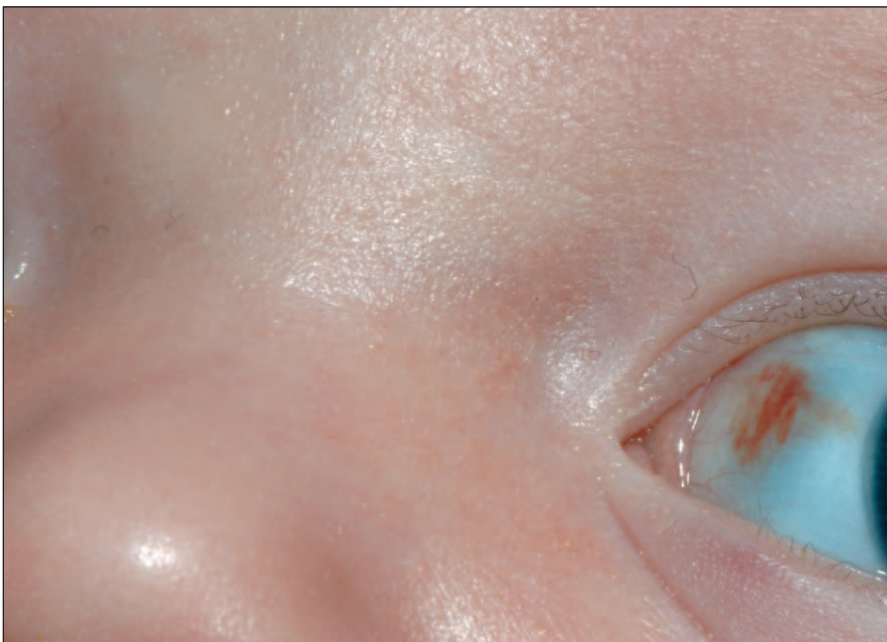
This 6-week-old presented with irritability and was under evaluation to rule out sepsis when subconjunctival hemorrhages (one of which is pictured here) and bloody LP were noted. Head CT revealed subarachnoid and subdural hematomas and brain contusions, and skeletal survey revealed multiple rib fractures. Caregiver acknowledged inflicting injuries, including squeezing the infant's torso on multiple occasions.
